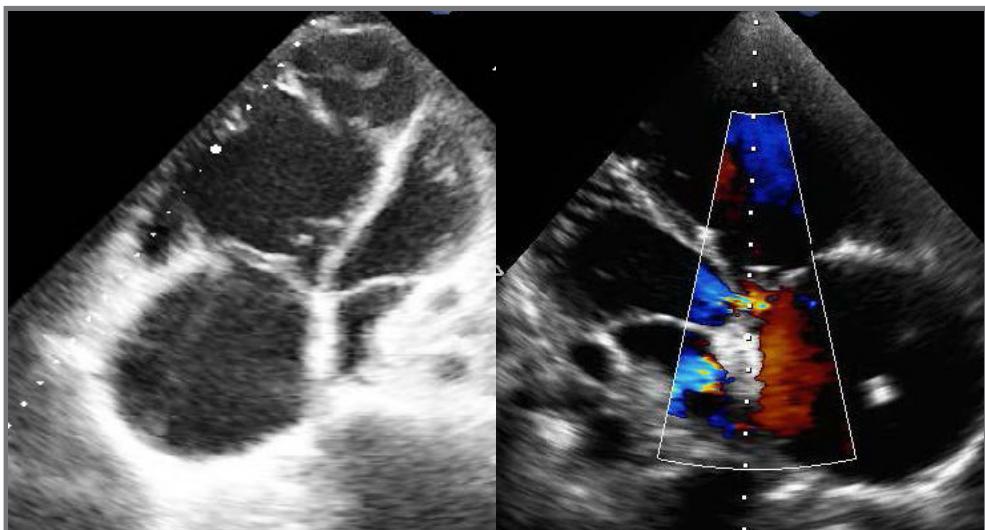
Same patient as in Figure 3, demonstrating situation before and after intervention, with the shunt through the AFR device apparent in color Doppler imaging (right image) in the long axis image. Note aortic regurgitation in the middle of the picture, the AFR device directly underneath it with the right-to-left shunt occurring through the device into the small left atrium.
